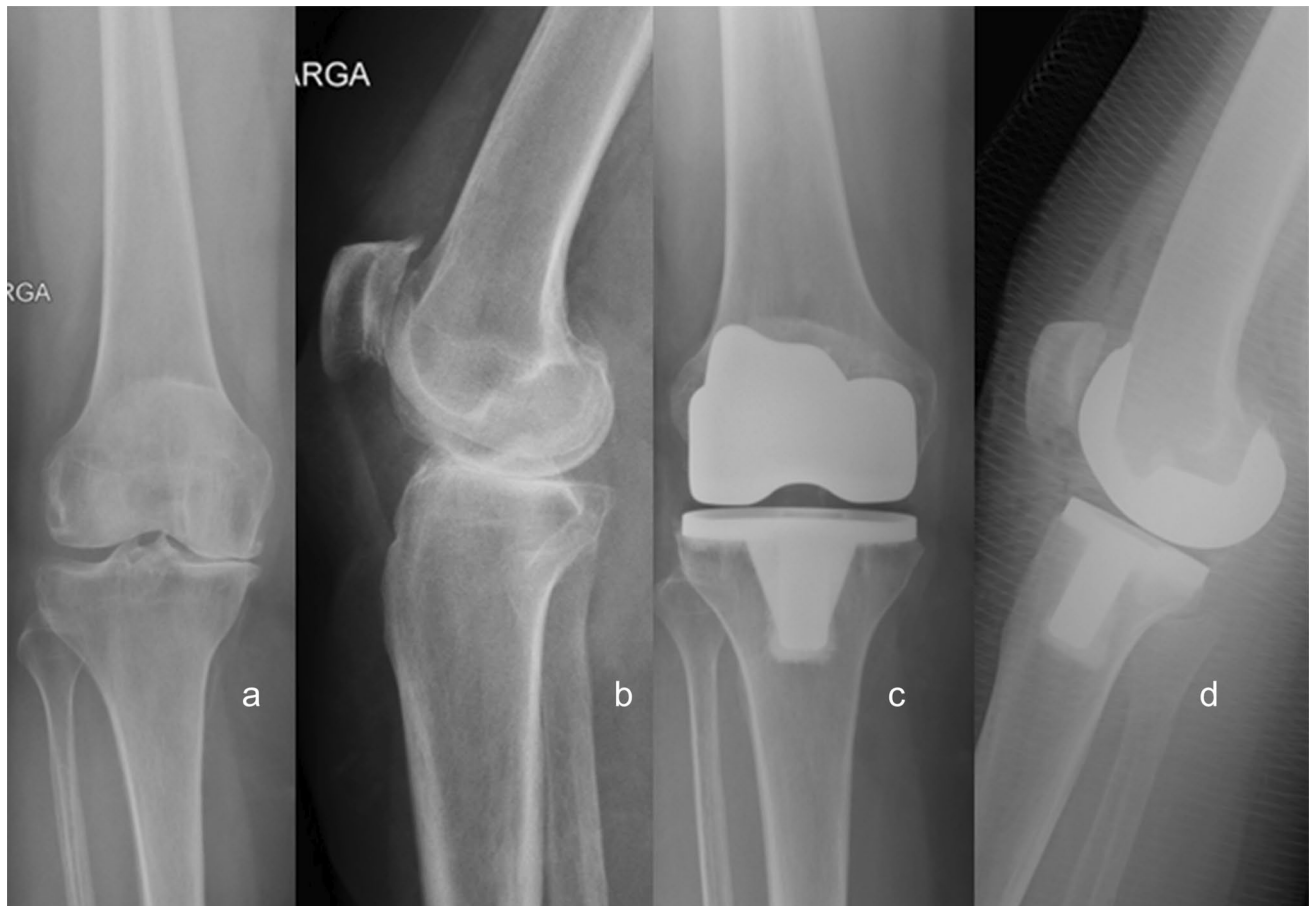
Case: a, b: preoperative AP and L view weight-bearing radiographs showing varus arthrosis. c, d: postoperative AP and L radiograph at 5-year follow-up showing proper femorotibial alignment, with no radiolucent lines present
